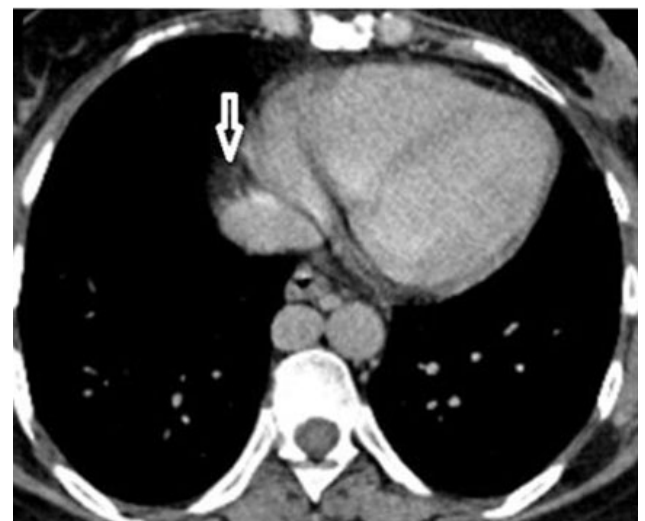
Enhanced abdomino-pelvic CT scan at the portal phase showing hepatic veins flowing directly into the right atrium (arrow).
